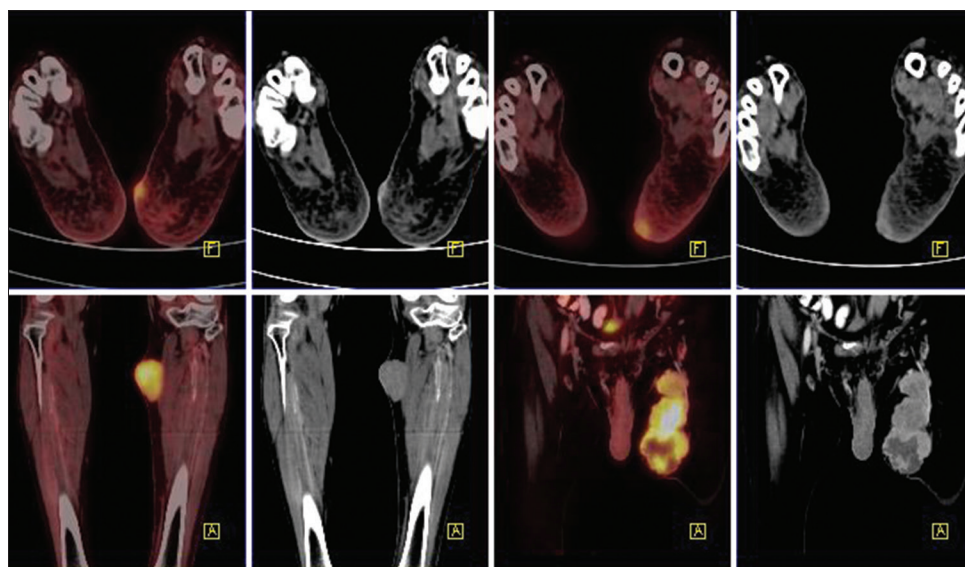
Positron emission tomography-computed tomography images: Axial (upper row) and coronal (lower row) images, few cutaneous lesions in left foot, subcutaneous mass lesion in left upper leg, and conglomerated mass lesions in left thigh
